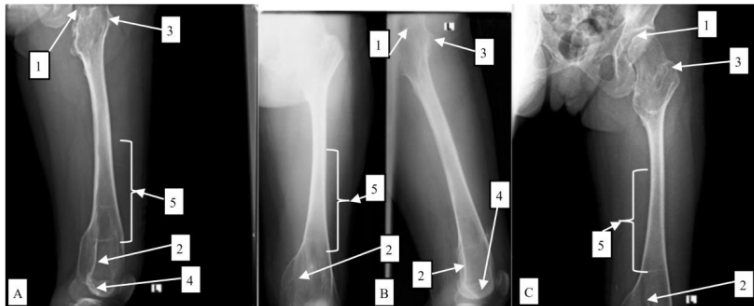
Left femur X-ray in AP (A), lateral (B), and oblique (C) positions. There is osteonecrosis of the left femoral head (1) and distal femur (2). There is a bulging of the left greater trochanter (3) and distal femur (4), which indicates an Erlenmeyer flask deformity (5)
